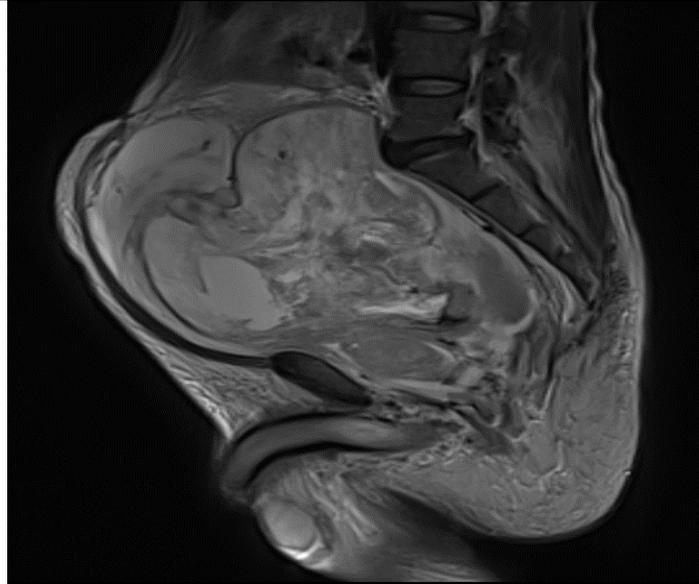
b) Pelvic MRI: T2 sagittal
